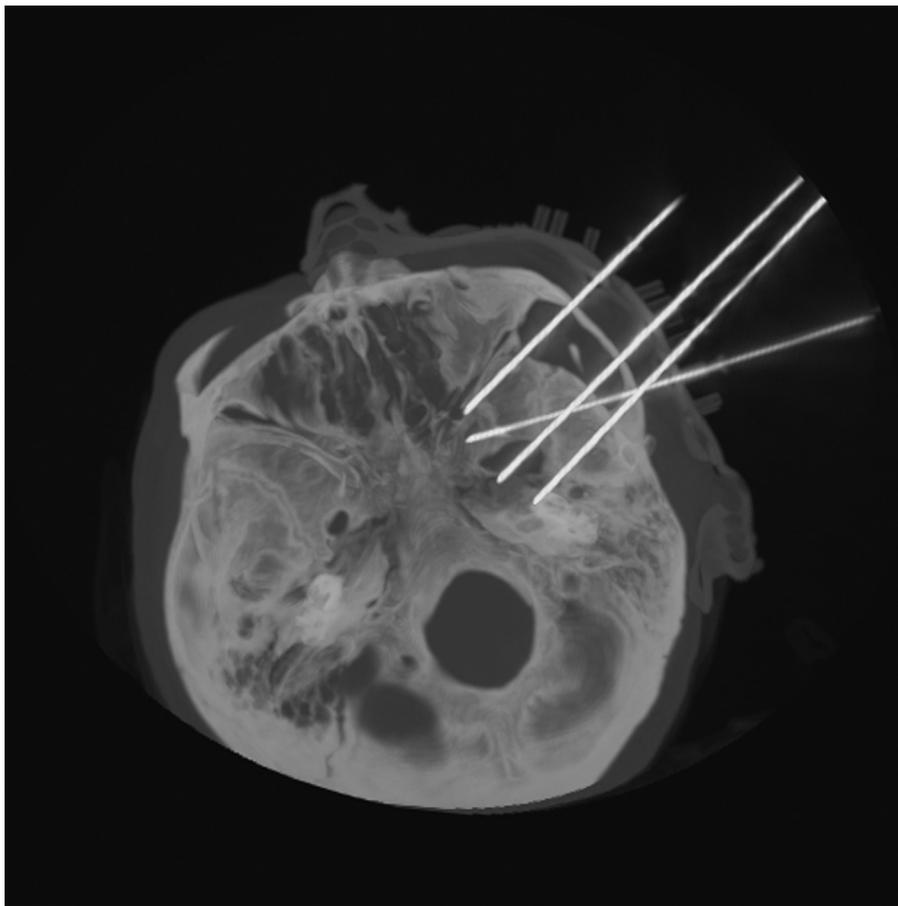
Computed tomogram after needle puncture.
